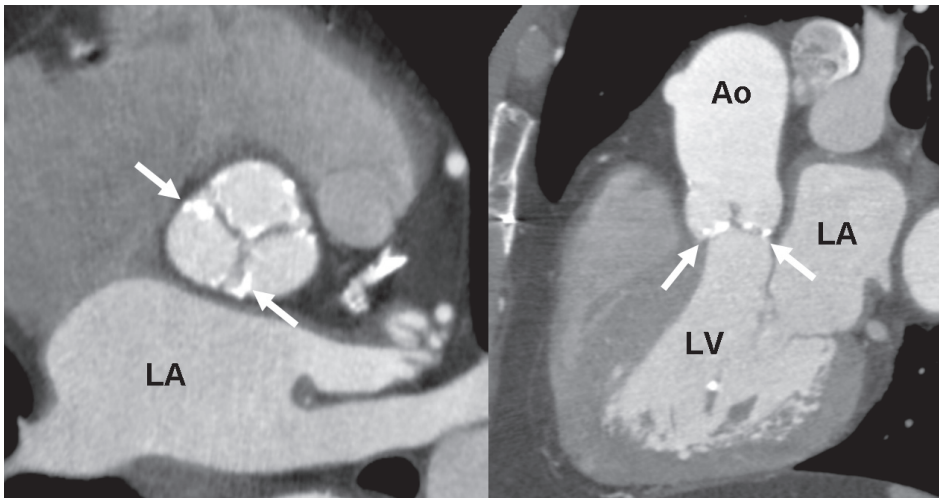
Multi-slice computed tomography images demonstrating a heavily calcified AV in a patient referred for percutaneous AV implantation. The left panel shows a short-axis reconstruction of the AV, indicating the calcifications on all leaflets (white arrows). In the right panel, the reconstructed sagittal view (similar to a parasternal long-axis view on transthoracic echocardiography) clearly demonstrates the extent and location of the calcifications. Ao = aorta; LA = left atrium; LV = left ventricle.
